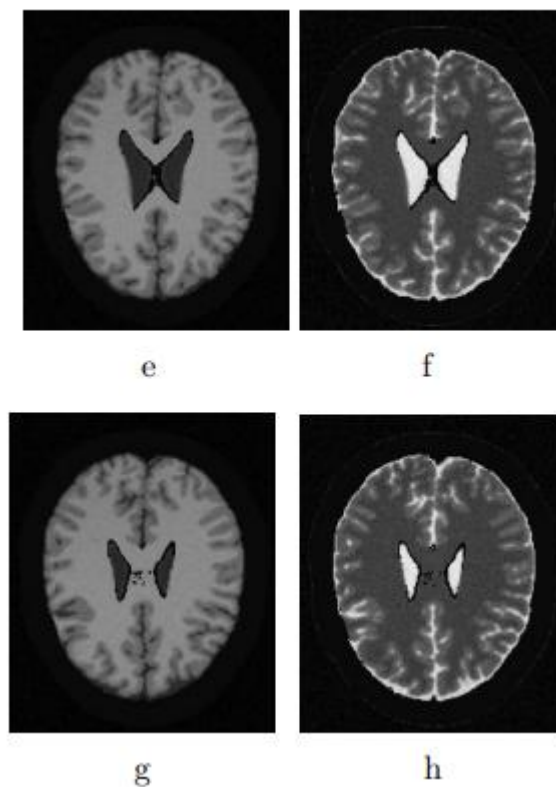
In the top row, we have a T1-weighted picture (a) and a T2-weighted image (b) of the brain taken in the Z85 plane, respectively). Second row displays T1- and T2-weighted pictures of the brain in the Z93 plane. In the third row, (e) T1-weighted photos (f) T2-weighted images from a brain MRI taken in the Z96 plane are shown. The fourth row displays the T1- and T2-weighted MRI of the brain in the Z100 plane.
